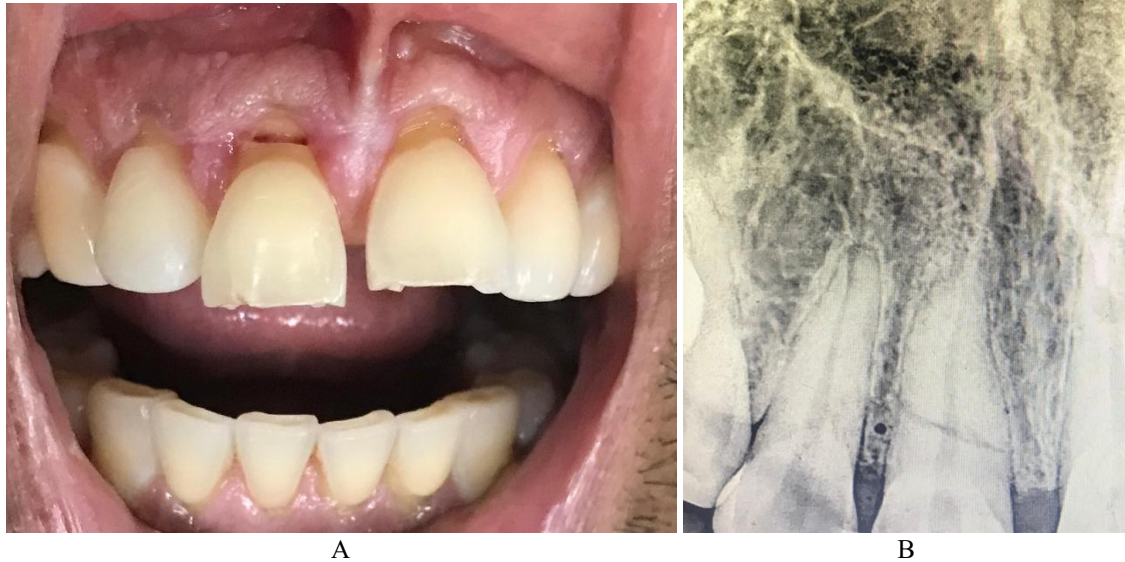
(A) Pre operative photograph of tooth 11, (B) Pre operative radiograph of tooth 11
